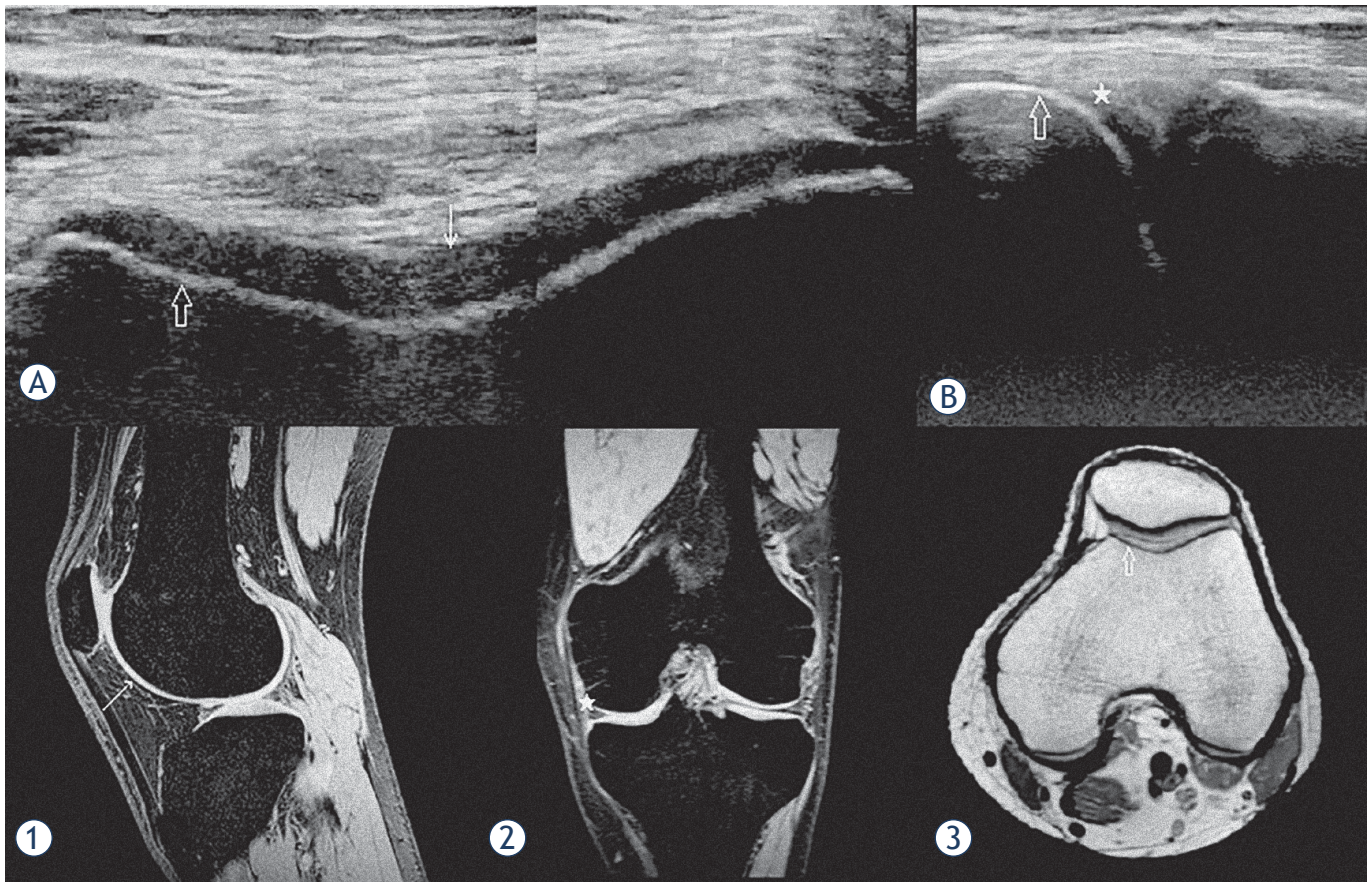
An example of a good concordance between HEAD-US and MRI. US images of the femoral trochlea in the transverse plane (A) and the medial femorotibial space in the coronal plane (B) are shown. T2* weighted MR images in the sagittal (1) and coronal (2) planes and a PD weighted MR image in the transverse plane (3) of the same knee are shown for comparison of the corresponding structures. The smooth surface, normal thickness and homogenous structure of the trochlear joint cartilage are shown in the US image (A) (white arrow); the corresponding intact cartilage is shown on MR image (1). The intact cortical bone of the medial femoral condyle (hollow arrow) is shown by US in the images (A) and (B); the corresponding cortical bone is depicted by MRI in the image (3). No signs of synovium hypertrophy are shown by US in the medial femorotibial recess (white star) in the image B; the corresponding recess confirming no synovium hypertrophy is shown by MRI in the image (2). On MRI, there were also no arthropathic changes in the parts of the joint not visualized by US. The images show a perfect concordance between US and MRI findings in this knee with no signs of haemophilic arthropathy.
